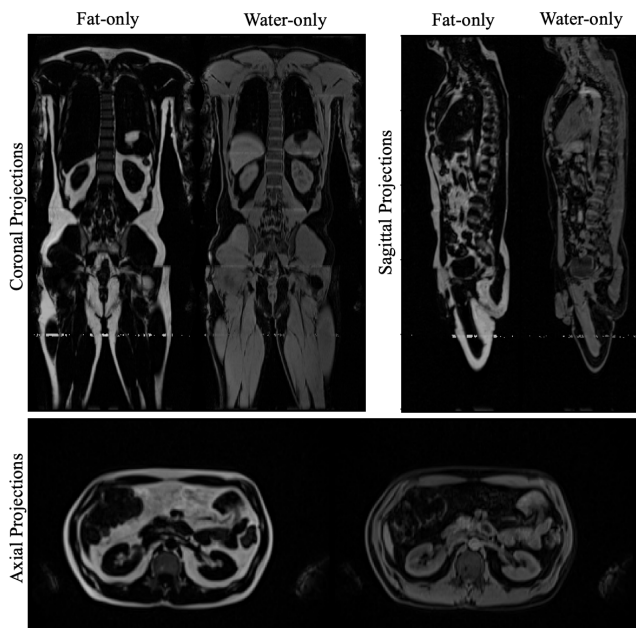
Coronal, sagittal and axial projections for fat-only and water-only Dixon MRI sequences.
